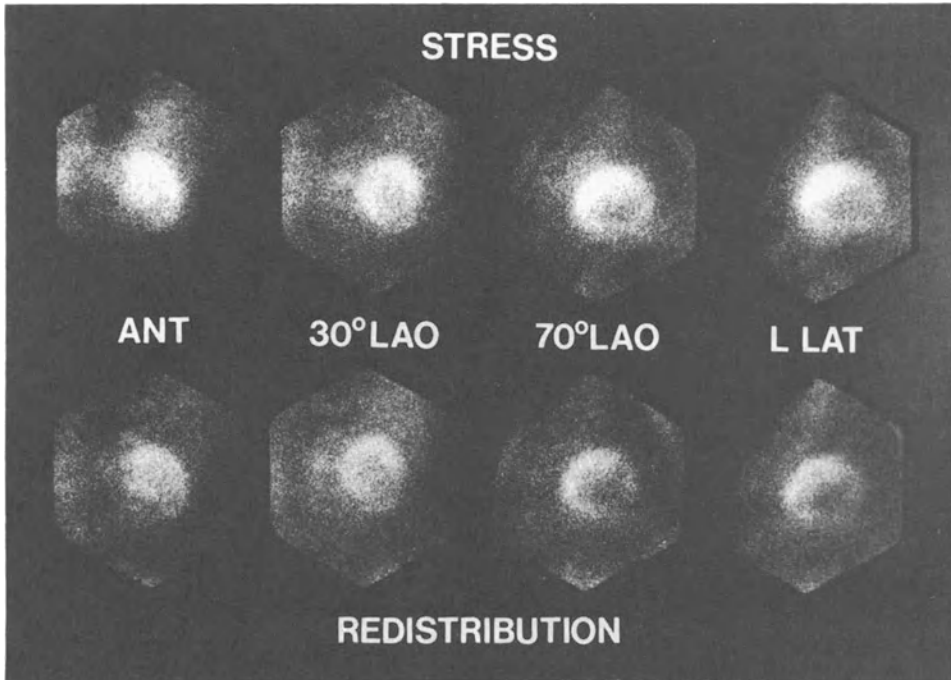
Normal myocardial perfusion scintigraphy with thallium-201 after stress in four different projections. Notice the uniform uptake of radiotracer throughout the left ventricular wall and the central defect due to the left ventricular cavity. ANT = anterior; 30° LAO = 30-degree left anterior oblique; 70° LAO = 70-degree left anterior oblique; LLAT = left lateral.
